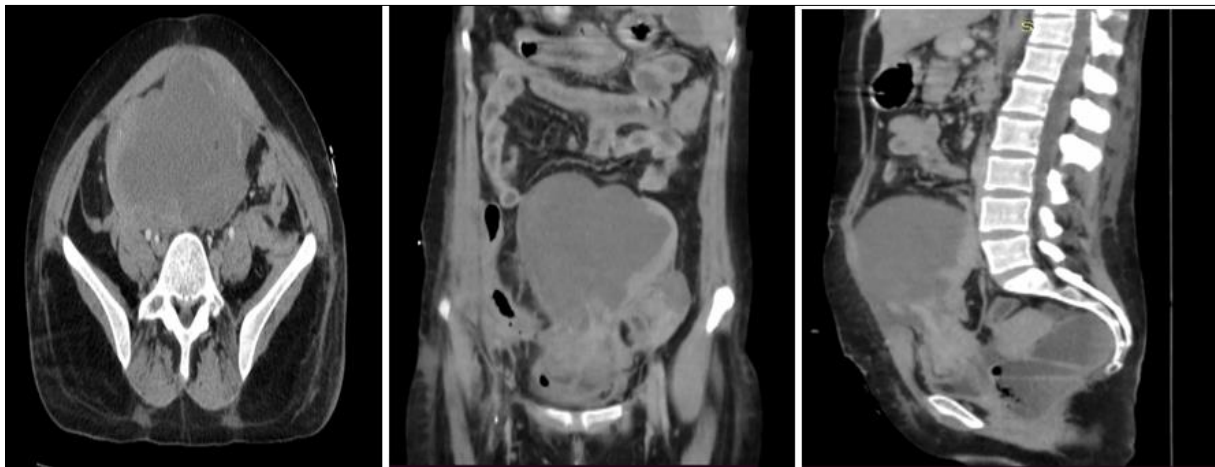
CT scan after contrast injection: absence of enhancement of the uterus in the left corporo-fundal portion, contrasting with normal enhancement on the right side
